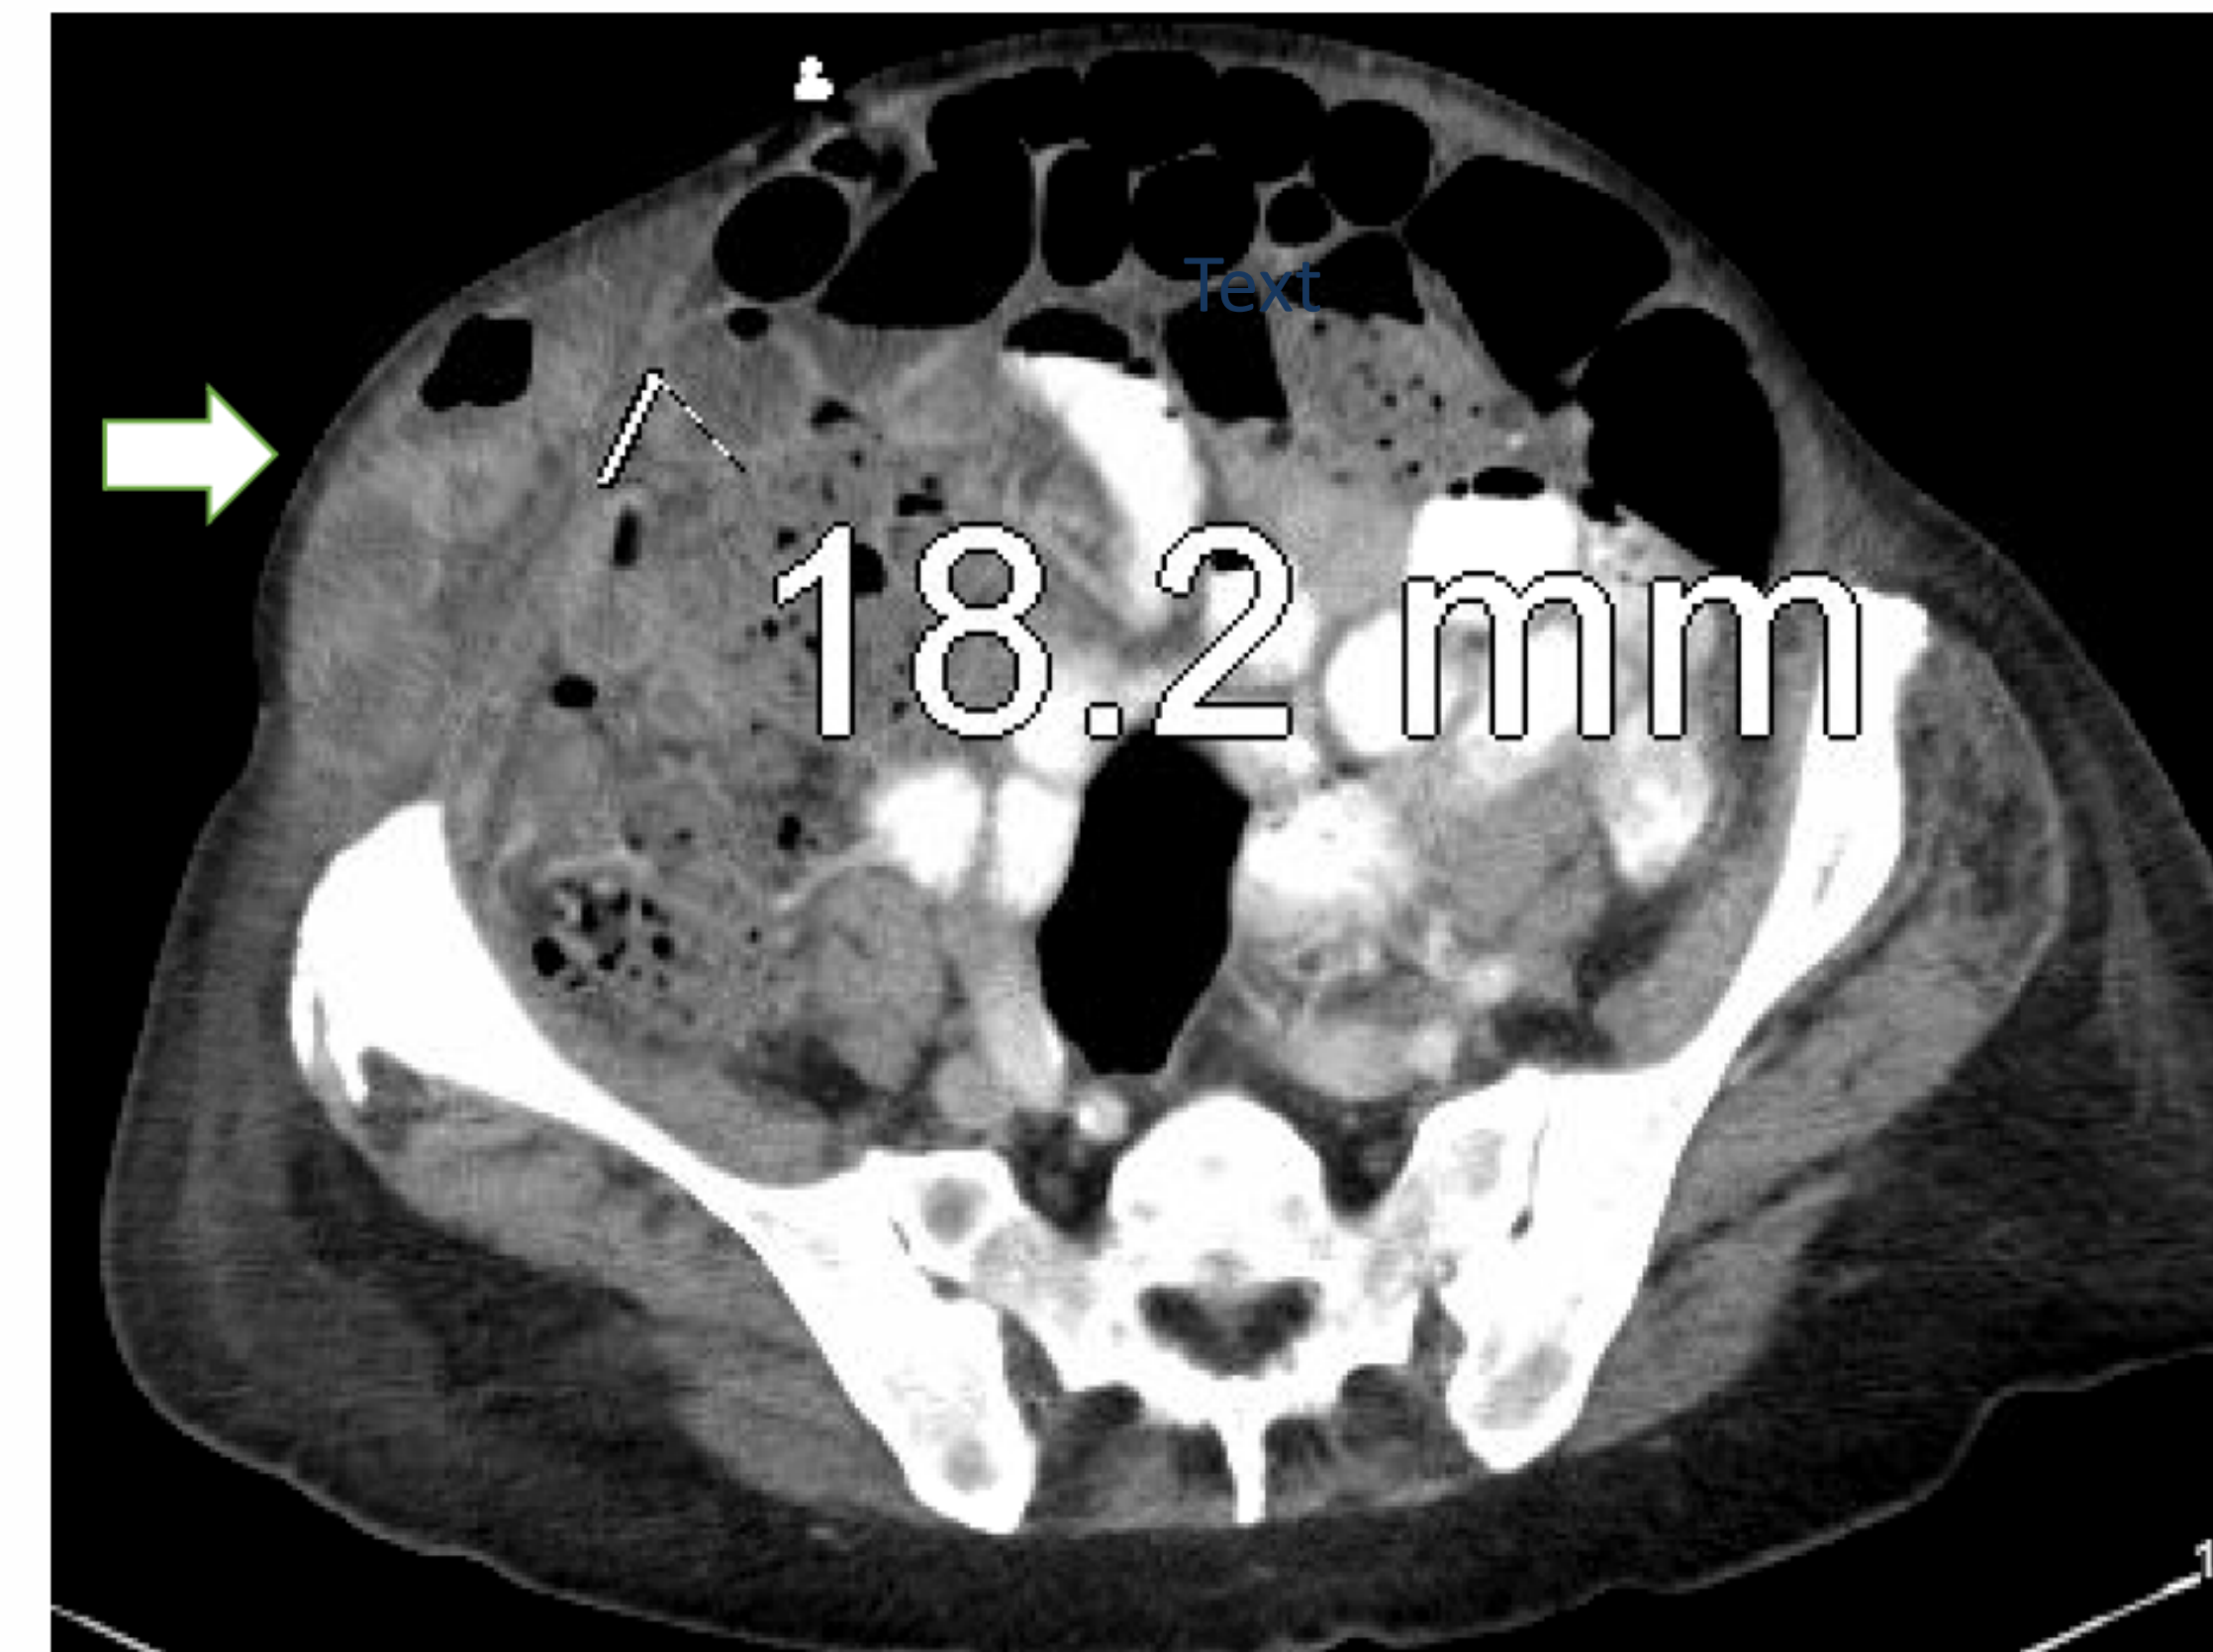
CT Abdomen demonstrating small bowel herniating through an 18.2mm fascial defect which had evolved from an initial 8mm robotic trocar.
